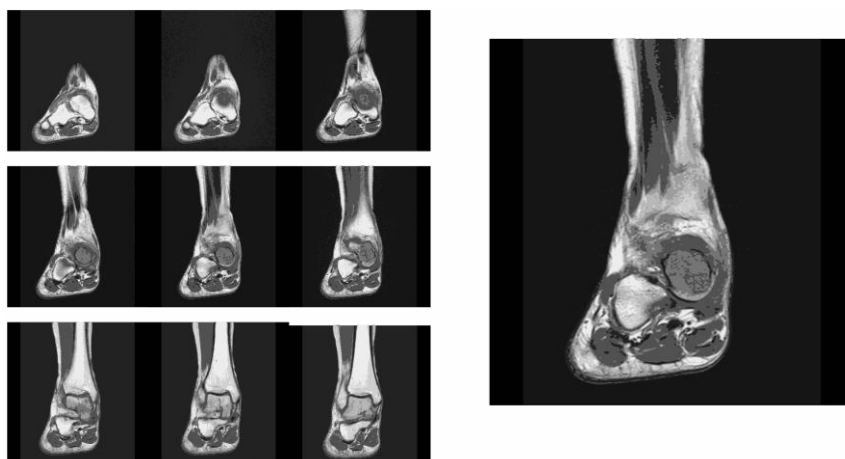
Right Ankle MRI T1W Coronal View.
